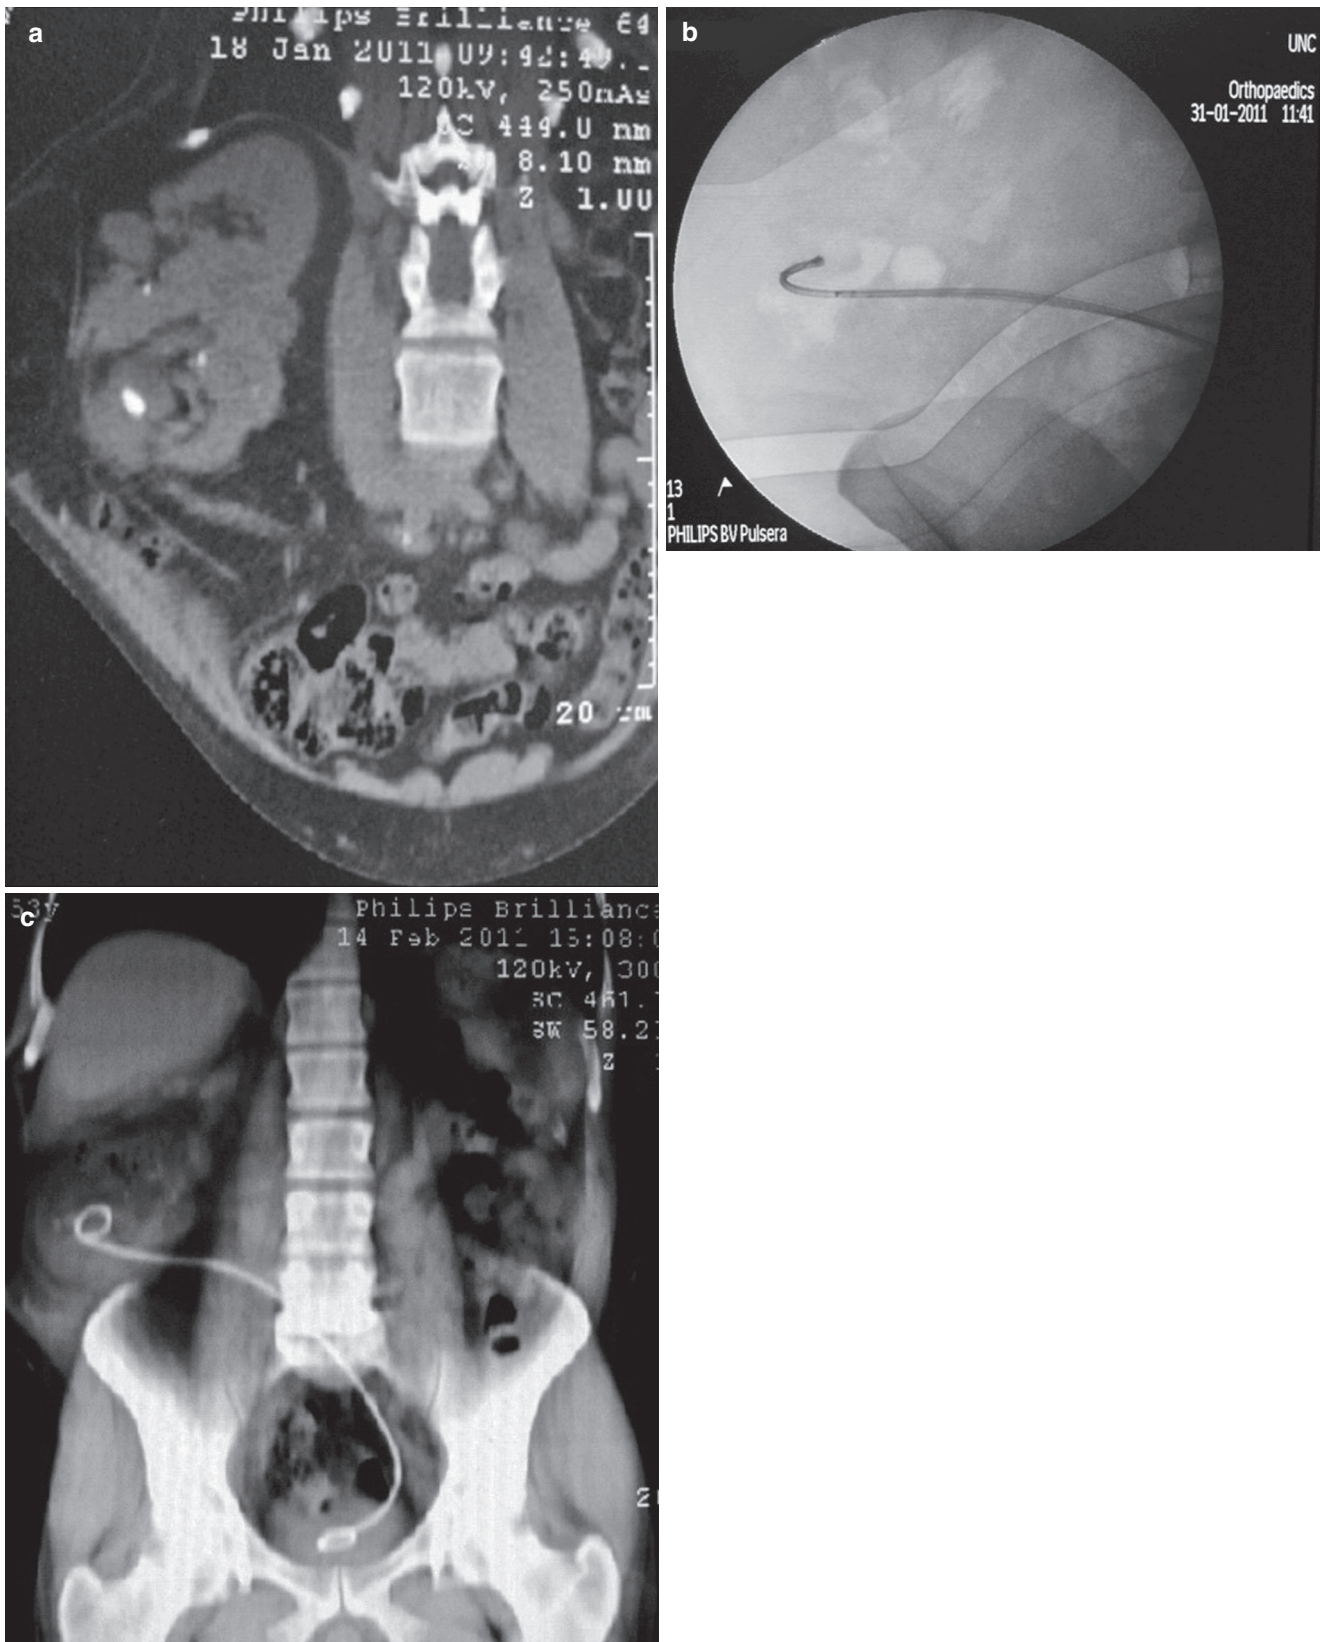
(a) Preoperative noncontrast computed tomography (NCCT), coronal-oblique view showing a stone in the renal pelvis of crossed fused ectopic left kidney in the *right* iliac region. (b) Intraoperative
